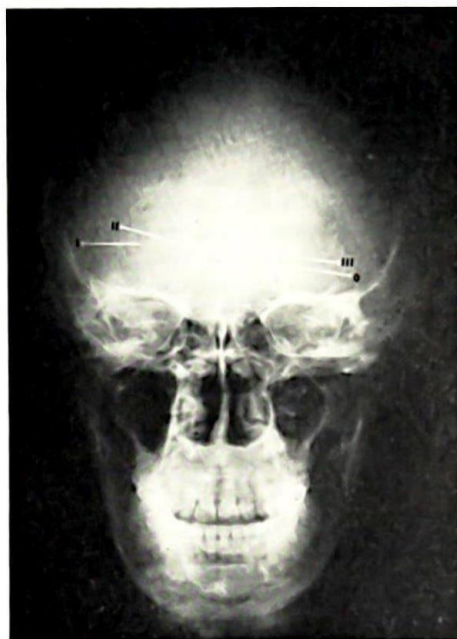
Skull X-ray of one of the authors (S.G.M.) with the four pineal glands shown in Fig. 1 superimposed and marked by pins. Degree II just recognizable and degree III definitely visible.
